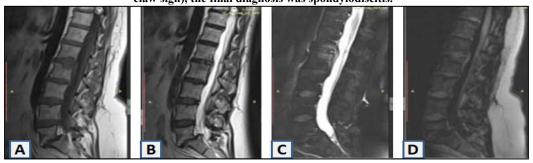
A 48 years old female patient presents with fever and back pain. A: Sagittal T1 demonstrate L1-2 endplate hypo signal intensity. B: Sagittal T2 demonstrate L1-2endplate hyper signal intensity. C: Sagittal STIR demonstrates L1-2 endplate hyper signalintensity. D: Sagittal DWI demonstrates L1-2 endplate normal DWI, the final diagnosiswas spondylodiscitis.
